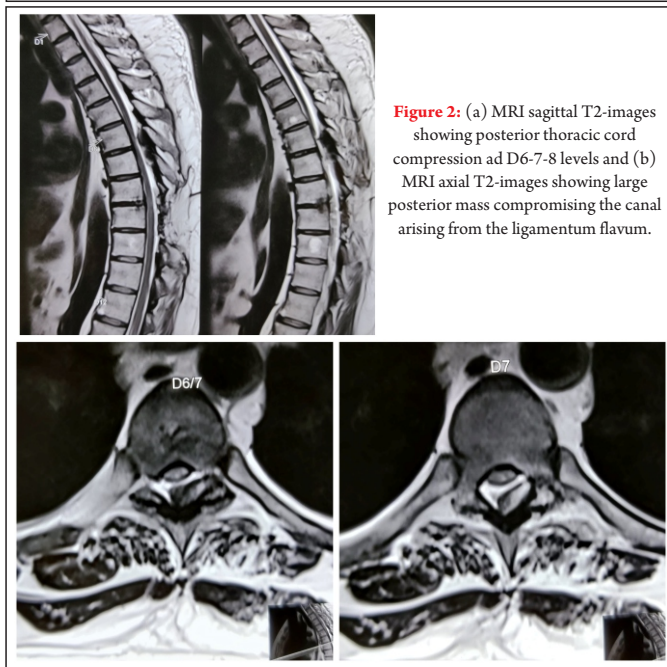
(a) MRI sagittal T2-images showing posterior thoracic cord compression at D6-7-8 levels and (b) MRI axial T2-images showing large posterior mass compromising the canal arising from the ligamentum flavum.
